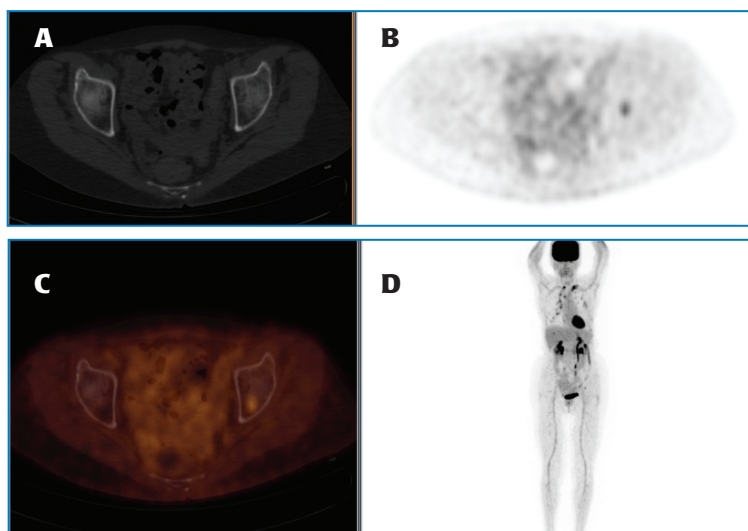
The image (B) shows subtle FDG focus on PET (top right). There is no significant abnormality on CT (A) (top left). A fused PET/CT (C) demonstrates focal FDG uptake in the left acetabulum (bottom left). There is a maximum intensity projection PET image (D) (bottom right).
